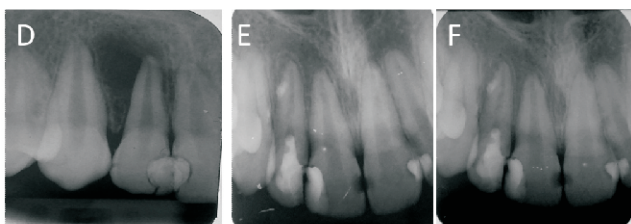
(D) Pre-treatment radiograph of the maxillary right lateral incisor showing a large periapical radiolucency. (E) Periapical radiographs obtained at the 6 months follow-up, shows evidence of healing after REPs. (F) Periapical radiograph obtained after 18 months, the periapical radiolucent lesion was completely healed and formation of a calcified bridge. Tooth was asymptomatic and responded to pulp sensibility tests.
